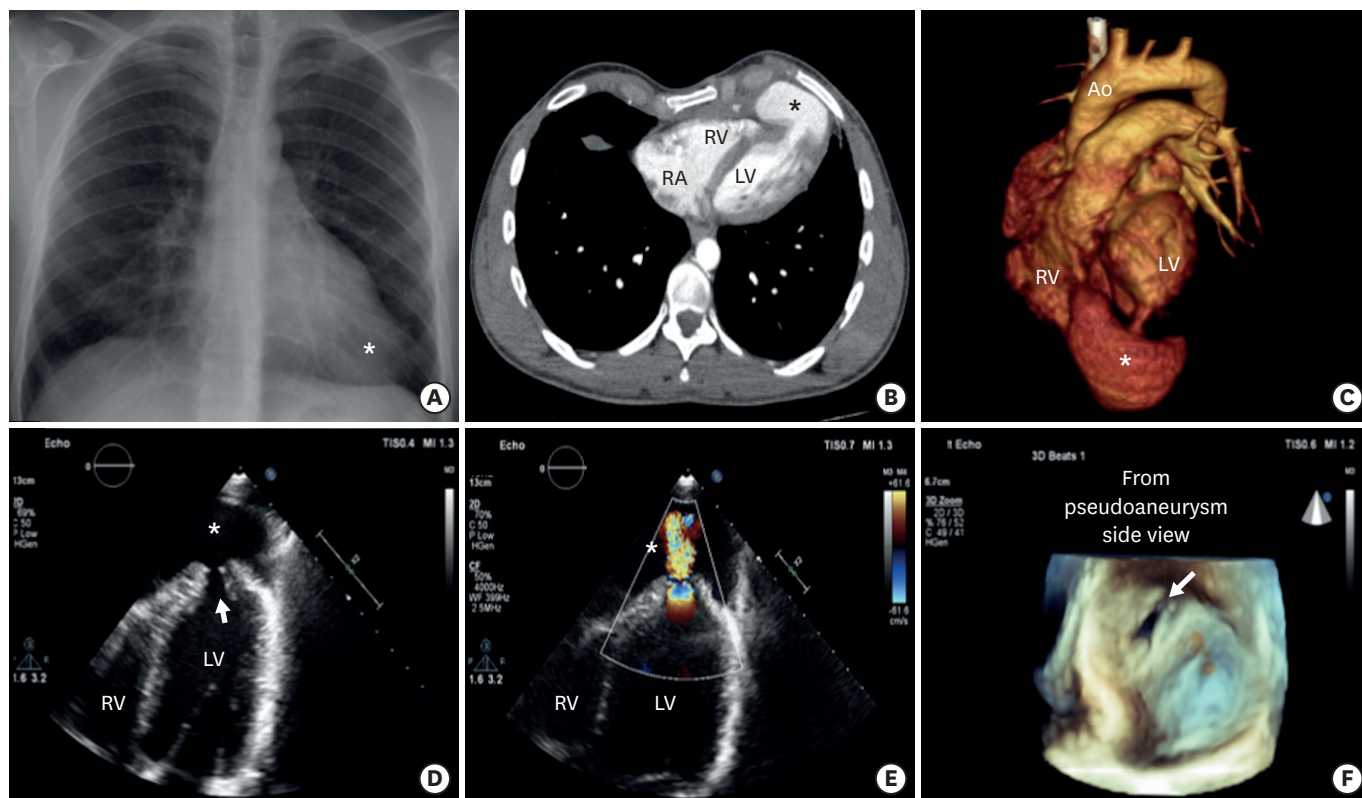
(A) Chest X-ray showed enlarged apical cardiac silhouette (asterisk). (B) CT angiography transvers view showing large apical pseudoaneurysm (asterisk). (C) Three-dimensional CT angiography showing pseudoaneurysm(asterisk) and connection to the LV cavity through a neck. (D) Transthoracic echocardiography apical 4 chamber view showing left ventricle apical pseudoaneurysm(asterisk) and entrance of pseudoaneurysm (arrow). (E) Transthoracic echocardiography apical 4 chamber colour doppler view showing pseudoaneurysm (asterisk) was connected to the LV cavity. (F) Three-dimensional echocardiography view from pseudoaneurysm side showing pseudoaneurysm entrance orifice of 2.5×1.5 cm. Ao = aortic; CT = computed tomography; LV = left ventricular; RV = right ventricular.
